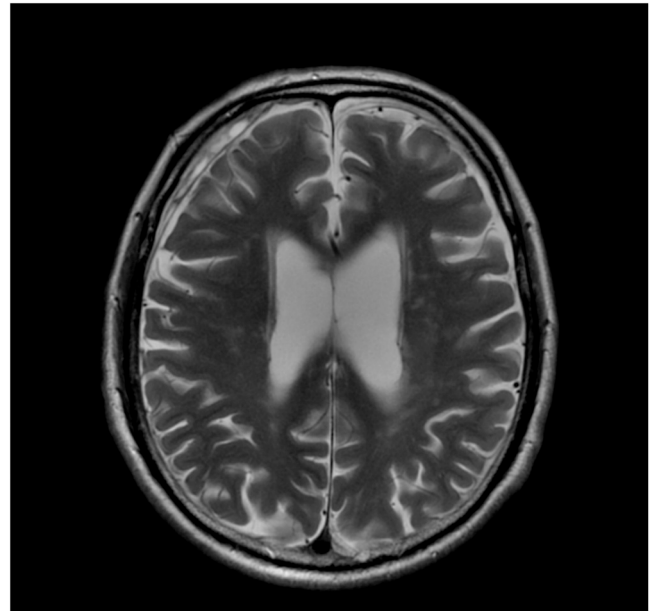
Preoperative brain MRI examination shows a bilateral crescent-shaped hyperdense lesion under the dura mater that compresses both hemispheres of the cortex, suggesting a bilateral chronic subdural hematoma (CSDH).
